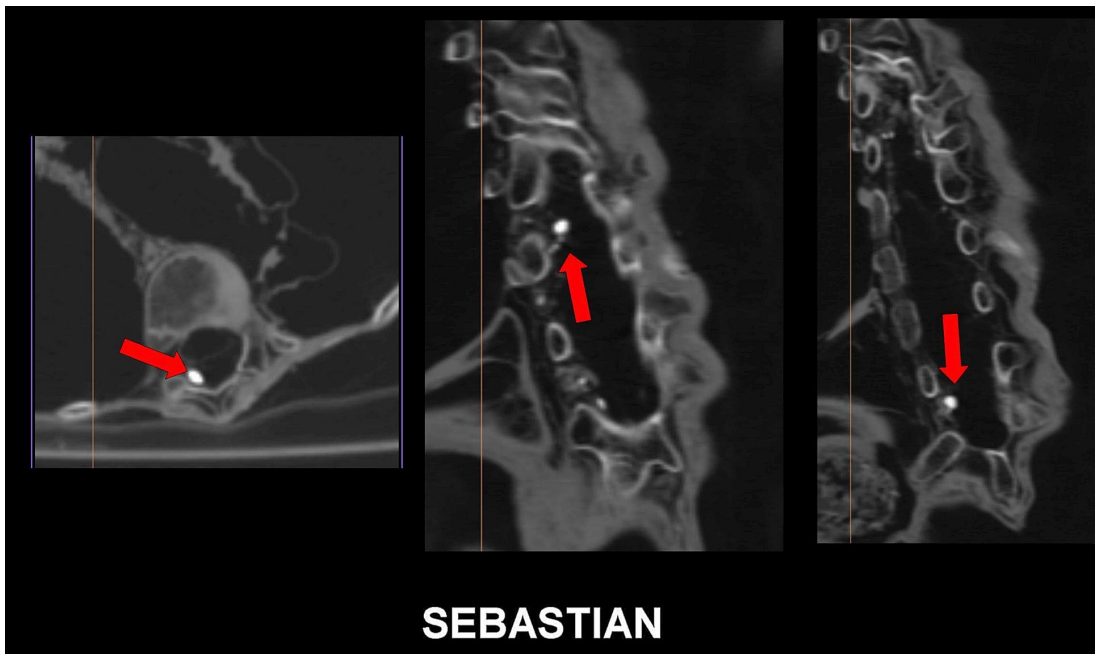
2D CT scans in axial (*left*) and sagittal (*middle and right*) projections showing 2 metallic foreign bodies or calcifications (*red arrows*) in mid and lower thoracic spine.
